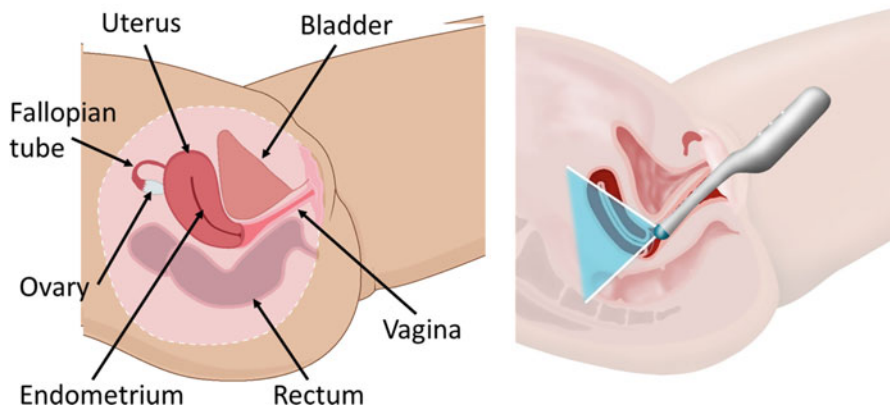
Female reproductive system with endovaginal transducer placement. When placed endovaginally, the ultrasound probe is placed directly against the cervix, preventing interference from any other tissue and allowing for a clearer imaging of female reproductive system changes compared to trans-abdominal imaging
